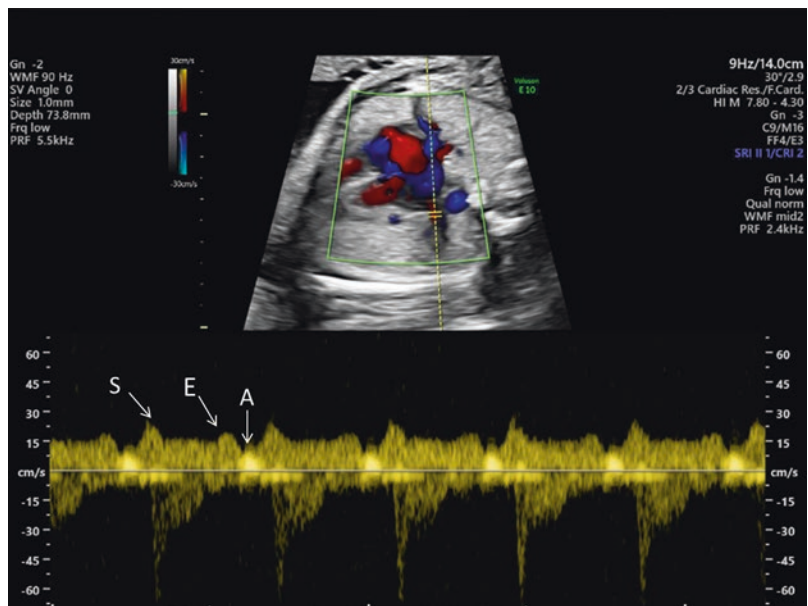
Pulmonary vein Doppler flow tracing with triphasic pattern consisting of a systolic (S), early diastolic (E), and atrial contraction (A) waves
